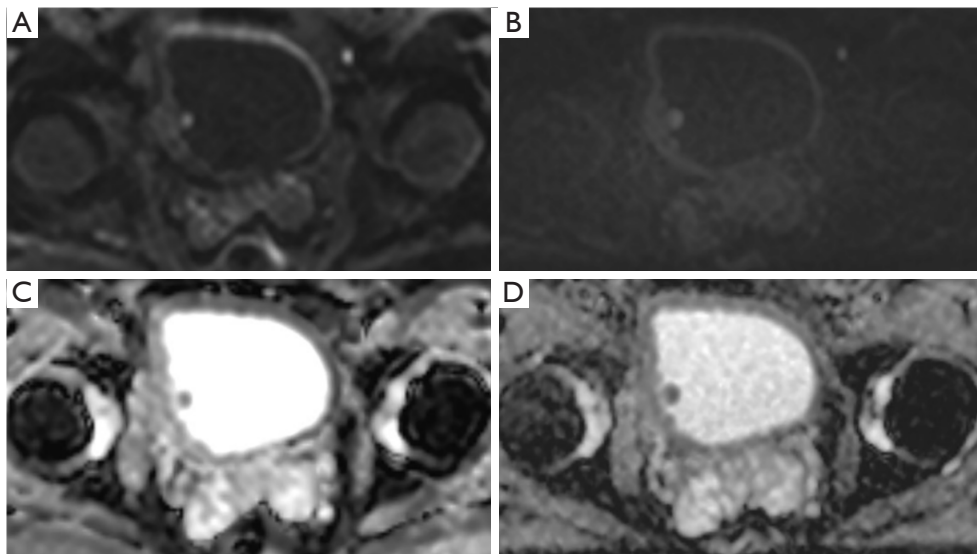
iShim DWI showing a clear tumor and bladder contour without image distortion (A), SS-EPI DWI showing a slightly blurred lesion and bladder contour and image distortion with substantial noise (B), iShim ADC showing a uniform urine signal (C), SS-EPI ADC showing an uneven urine signal (D). iShim, integrated slice-specific dynamic shimming; DWI, diffusion-weighted imaging; SS-EPI, single-shot echo-planar imaging; ADC, apparent diffusion coefficient.
